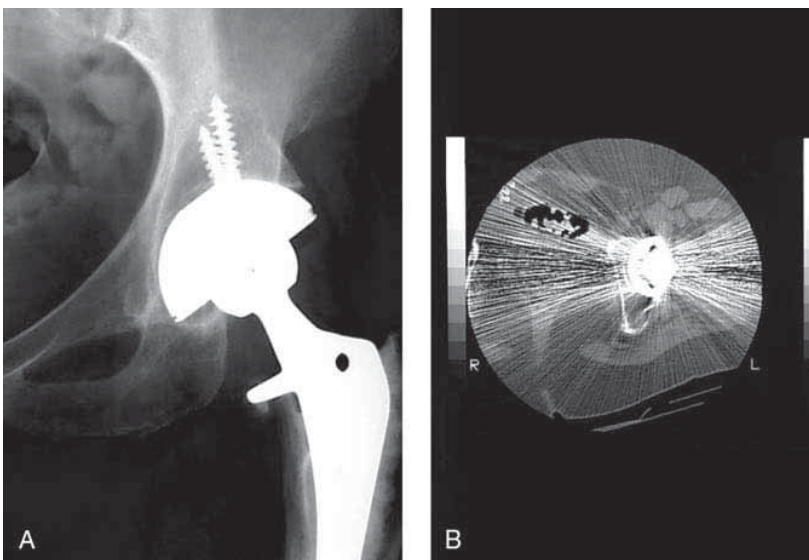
A, The components appear to be well positioned on the AP radiograph of the hip of a patient with recurrent dislocation. B, CT of the same hip, however, confirms a retroverted acetabular component. Revision of the acetabular component alone in this case was adequate to address the episodes of recurrent dislocation.
